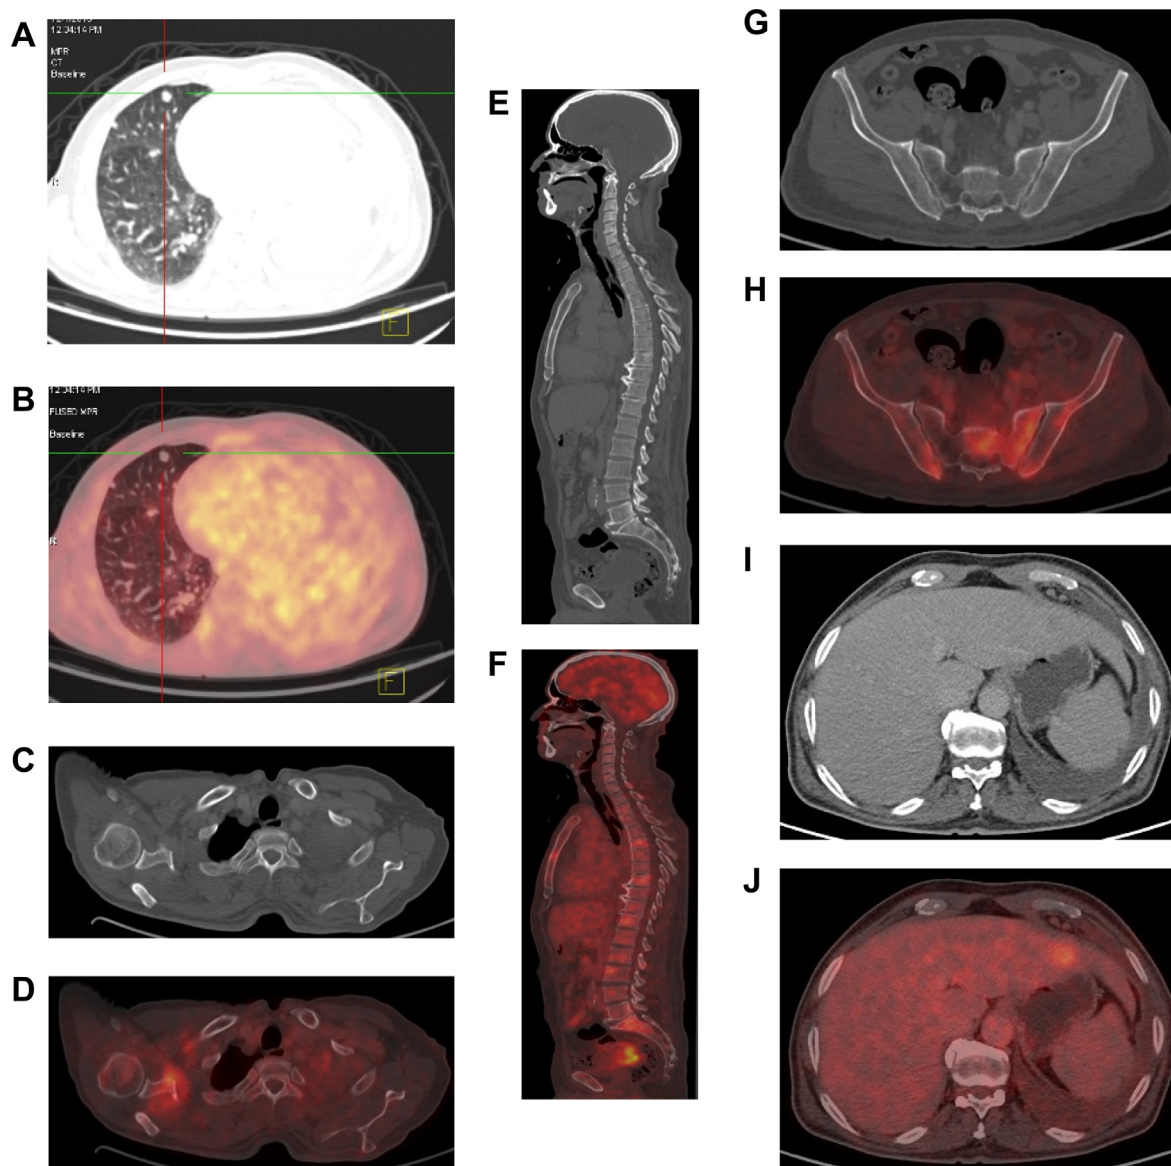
65 years male with pathologically proved right RCC underwent right radical nephrectomy with adjuvant chemotherapy and referred to PET –CT for FU. (a, b) Axial CECT and corresponding PET/CT images lung window showed left lung apex totally replaced by metastatic mass infiltrating the left pleural surfaces of heterogeneous FDG uptake, SUVmax up to 7, the mass is seen inseparable from left hilum, mediastinum and pericardium with multiple right pulmonary deposits. (c, d) CT and corresponding PET/CT bone window images showed FDG over-metabolism at the right scapula with SUVmax 5.6 while axial bone window CT showed no appreciable abnormality. (e, f) Sagittal CT and PET CT bone window image showed FDG uptake in DV6 (SUVmax 5.3), DV9 (SUVmax 4.8), DV12 (SUVmax 5.9), LV3 (SUVmax 6.2) and sacrum (SUVmax 6.5) and sagittal CECT showed no appreciable changes. (g, h) Axial CECT and corresponding PET/CT images showed FDG uptake in both iliac bones (SUVmax 5.2 and 6.1 respectively) with no anatomical changes at CECT. (i, j) Axial CECT and corresponding PET/CT images showed 2 cm hepatic deposit segment II (SUVmax 5.8).
